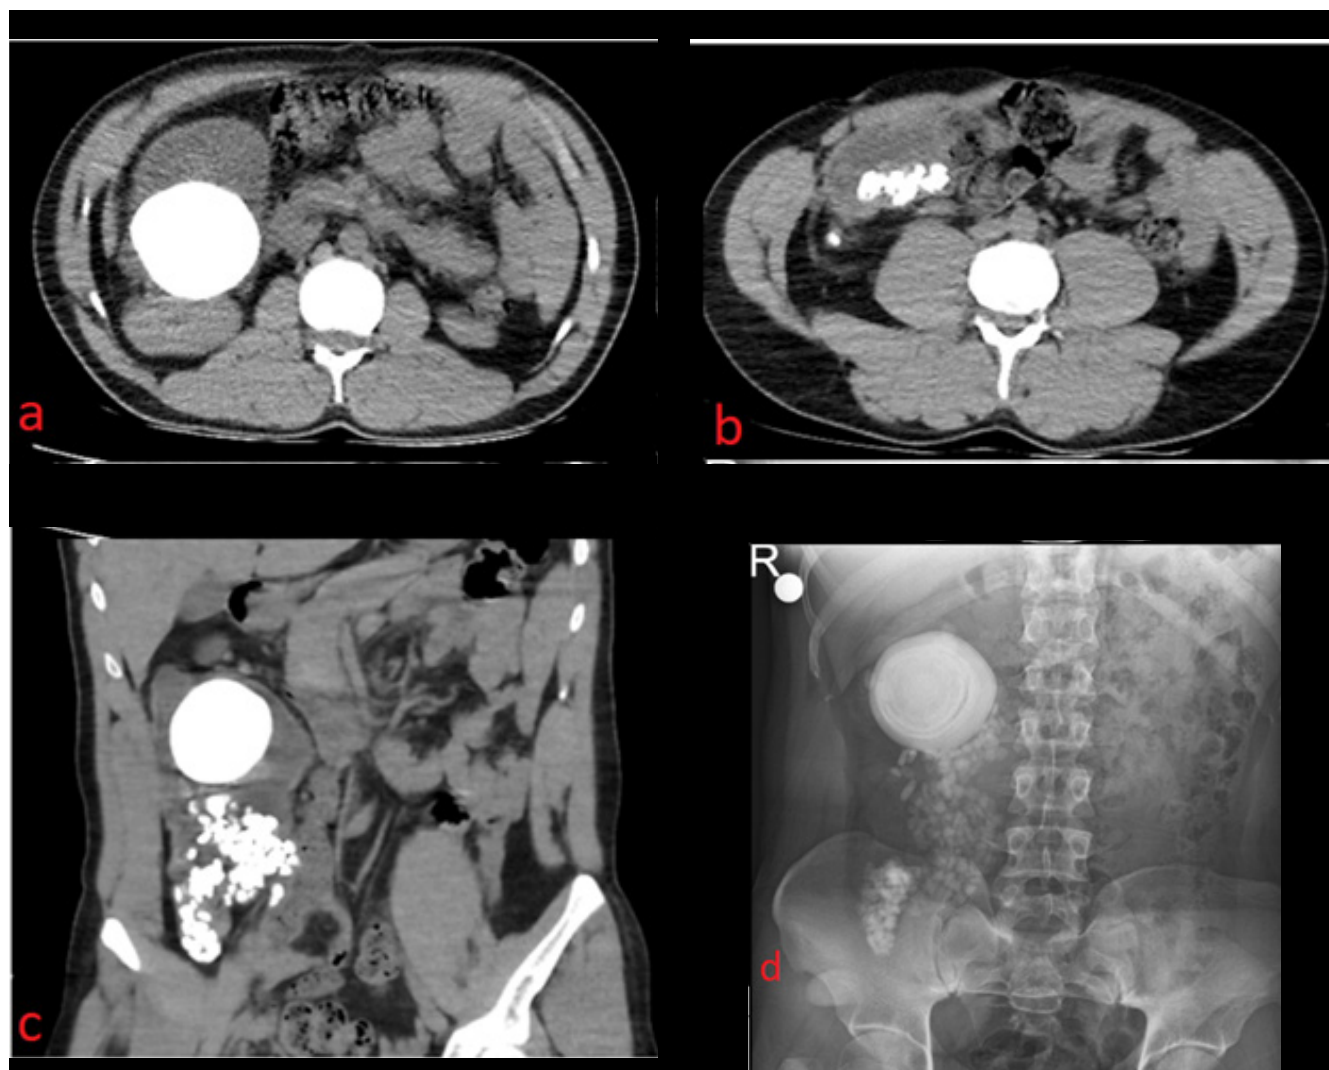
a. Axial computed tomography at the level of L1, b: Axial computed tomography at the level of L3, c: Coronal computed tomography, d: Plain urinary system radiograph
